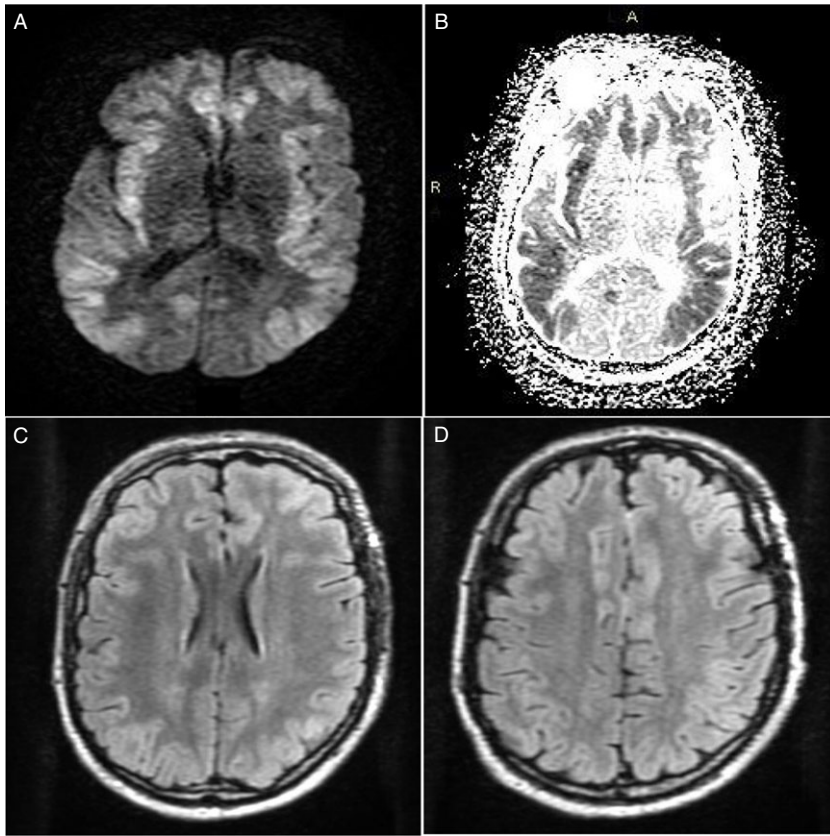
MRI images of the brain. (A) Diffusion-weighted image at the level of the thalamus showing cortical gyral diffusion restriction with relative sparing of the occipital cortex and deep gray structures. (B) Corresponding apparent diffusion coefficient imaging changes at the level of the thalamus showing abnormal signal in the cortical gyri with relative sparing of the occipital cortex and deep gray structures. (C) Fluid-attenuated inversion recovery image at the level of the superior aspect of the lateral ventricles and caudate showing cortical gyral high signal. (D) Fluid-attenuated inversion recovery image at the level of the superior cerebral hemispheres showing cortical gyral high signal with relative sparing of the parietal cortex.
